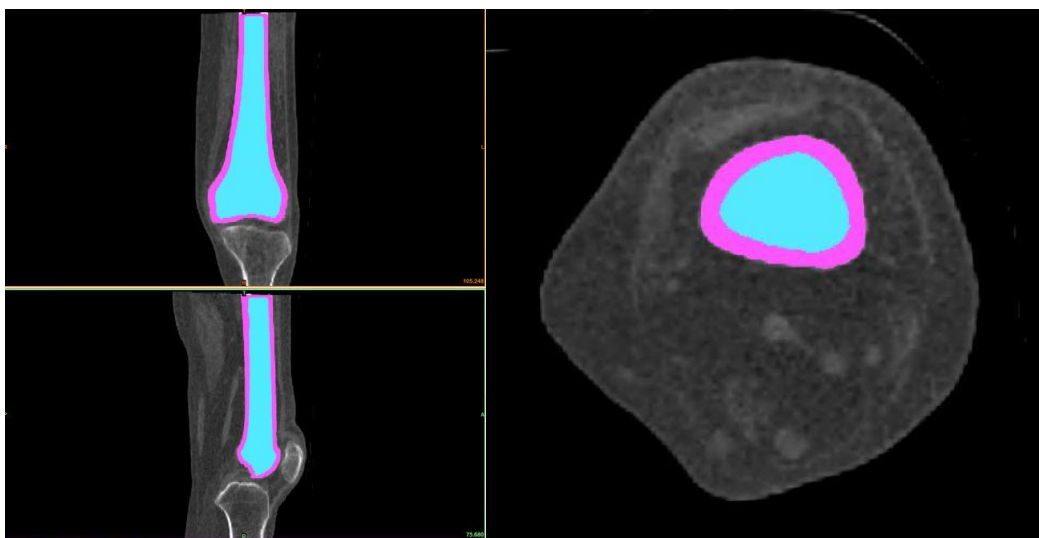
CT scans with manual identification of periosteal surface with cortical region (pink) and trabecular region (blue)
